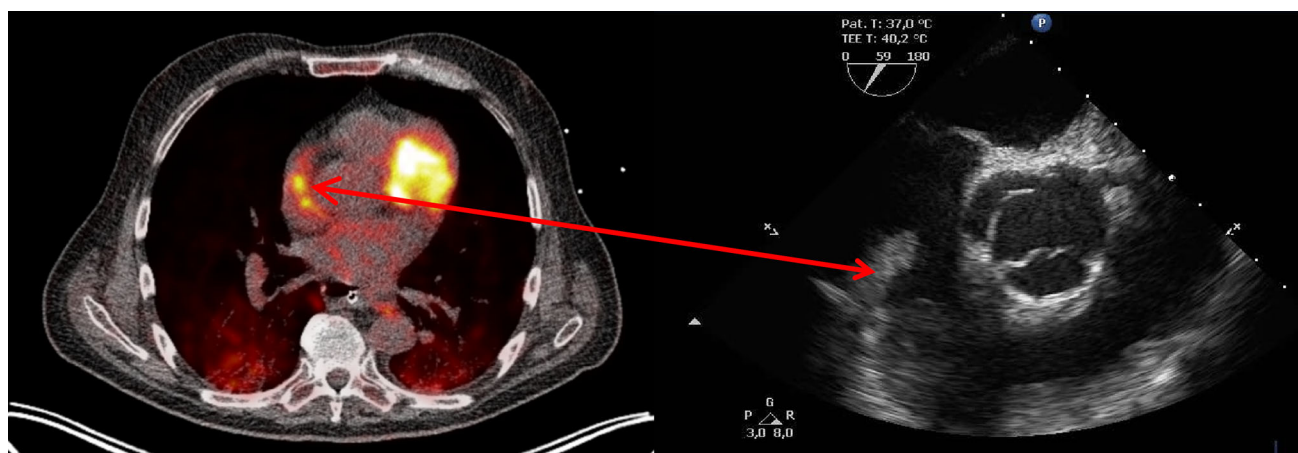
a PET/CT images of positive uptake in the right atrial appendage (arrow) of an immunocompromised patient with persisting blood cultures for *E. faecium*, *S. epidermidis* (CNS)
